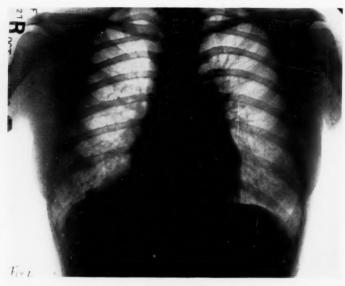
X-ray before bronchoscopy showing shadow in mesial part lower right chest due to atelectasis.
